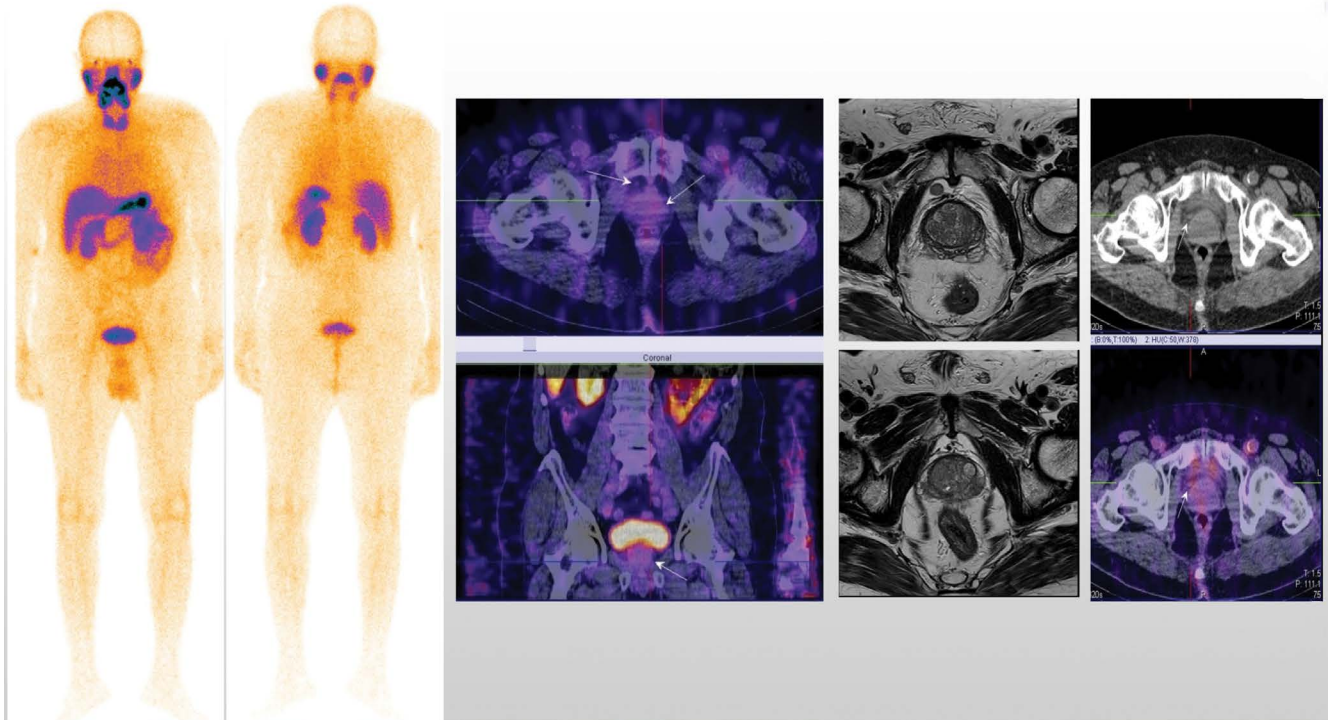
M/73yr with prostate cancer, T4N1M0, G3, GI = 9 (4 + 5). Cytoreductive radiotherapy (03/2019) and androgen deprivation therapy. PSA = 0.30 ng/mL (06/2019). Whole-body scan and target ^{99m}Tc Tc-PSMA-T4 SPECT-CT imaging showed enlarged prostatic gland and perivesical lymph nodes with intensive tracer uptake corresponding to MRT images. Disease persistence
